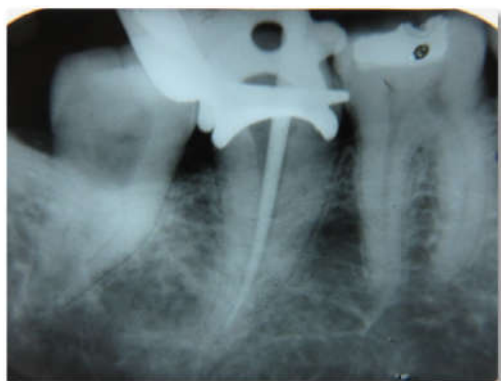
c Master cone radiograph
